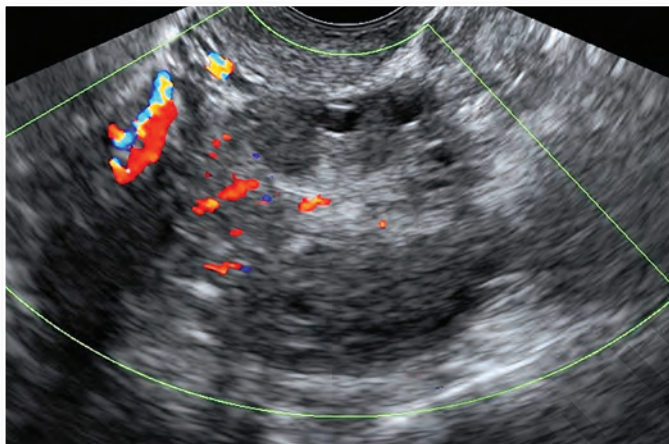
Transvaginal color Doppler imaging shows increased intraovarian vascularity
